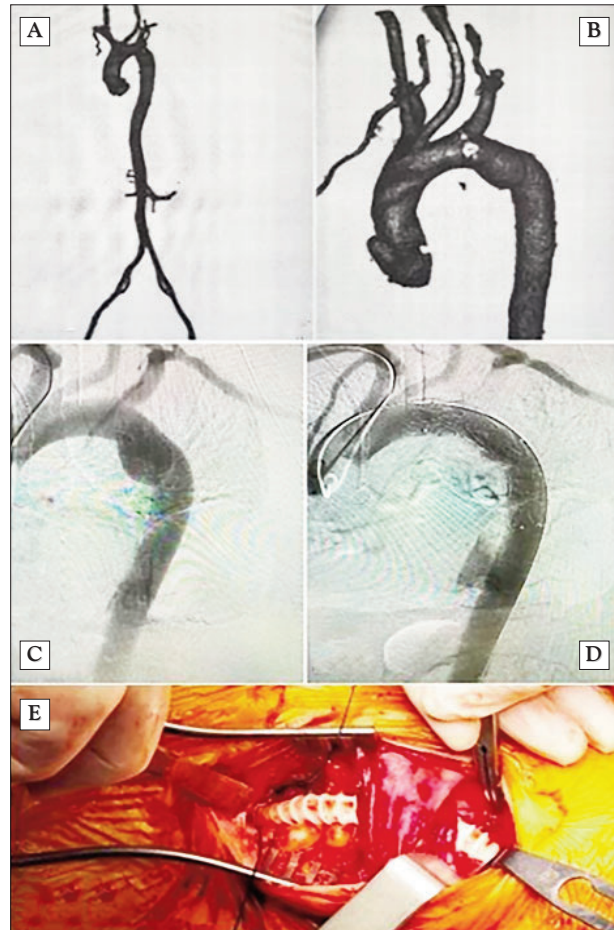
Case Report I imaging: (A,B) - 3D-CT preprocedural reconstruction of the aorta and close-up on the lesions of the Aortic Arch (left side projection); angiographic image before (C) and after (D) positioning of an E-VITA Thoracic 3G Straight Open of dimensions 26/26 x 130 mm downstream of the LCCA – zone 2 Ishimaru – and plugging of the LSA post the device implantation; (E) - Intraoperative aspect of the carotid-subclavian bypass.
